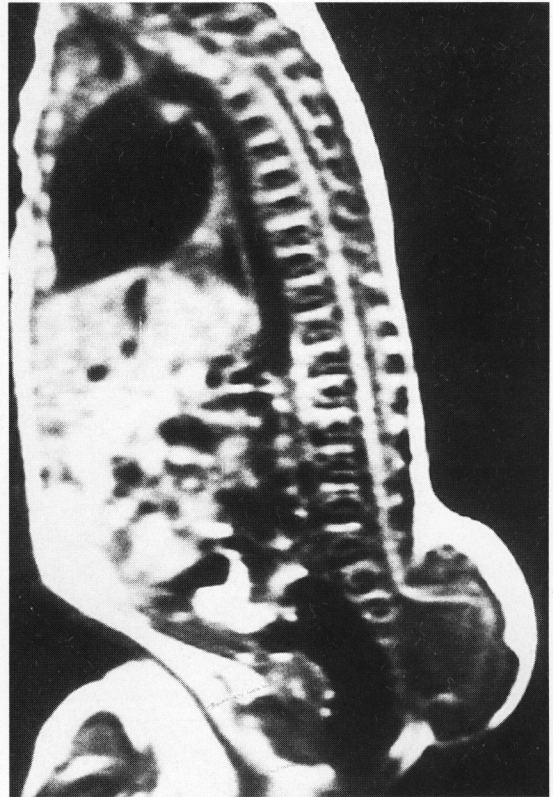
T1-weighted magnetic resonance image, sagittal view, shows an expanded, syringohydromyelic spinal cord that appears to terminate at the mid-sacral level. At the cord terminus, the central canal opens into a large cyst. At surgery, this terminal cyst was found to communicate with the dilated central canal of the spinal cord, resulting in the classification of this anomaly as a myelocystocele. The meningocele is also visualized ventral to the dorsal cyst which is the continuation of the central canal.
